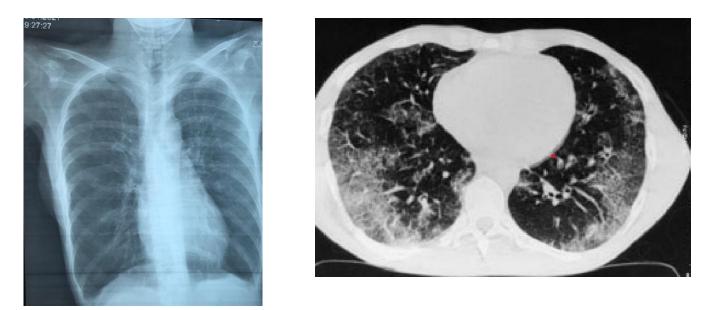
(A and B): A: Chest X-ray showing hyperinflated lung fields. B: CT Scan chest with contrast showing Patchy mosaic attenuation, septal thickening, paraseptal emphysematous changes in both apices, large bullae formation. Findings suggestive of EGPA.
